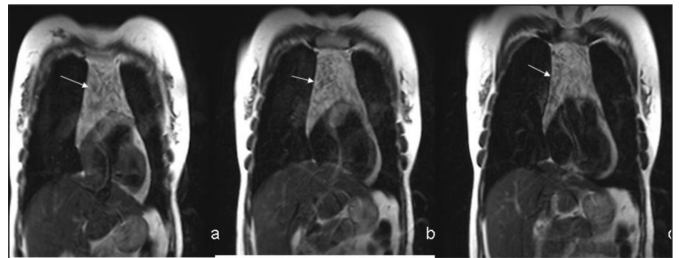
T1-weighted coronal MRI of a 34-year-old female patient (the same patient in Figure 2) shows a hyperintense mass when compared to muscle (fat containing mass).
